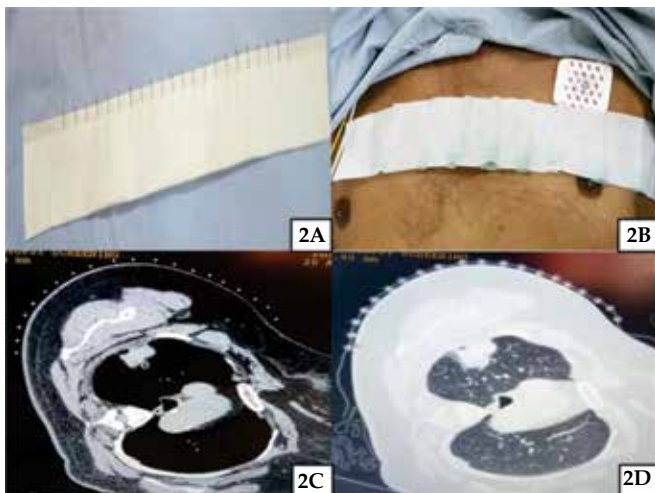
Photograph showing (A) multiple paper pins attached to adhesive for marking the site of biopsy, (B) multiple needles attached to the adhesive on the patient's chest before computed tomography and (C, D) computed tomography of chest (mediastinal and lung window) showing multiple paper pins or needles attached to the adhesive on the patient's chest with lung mass.
